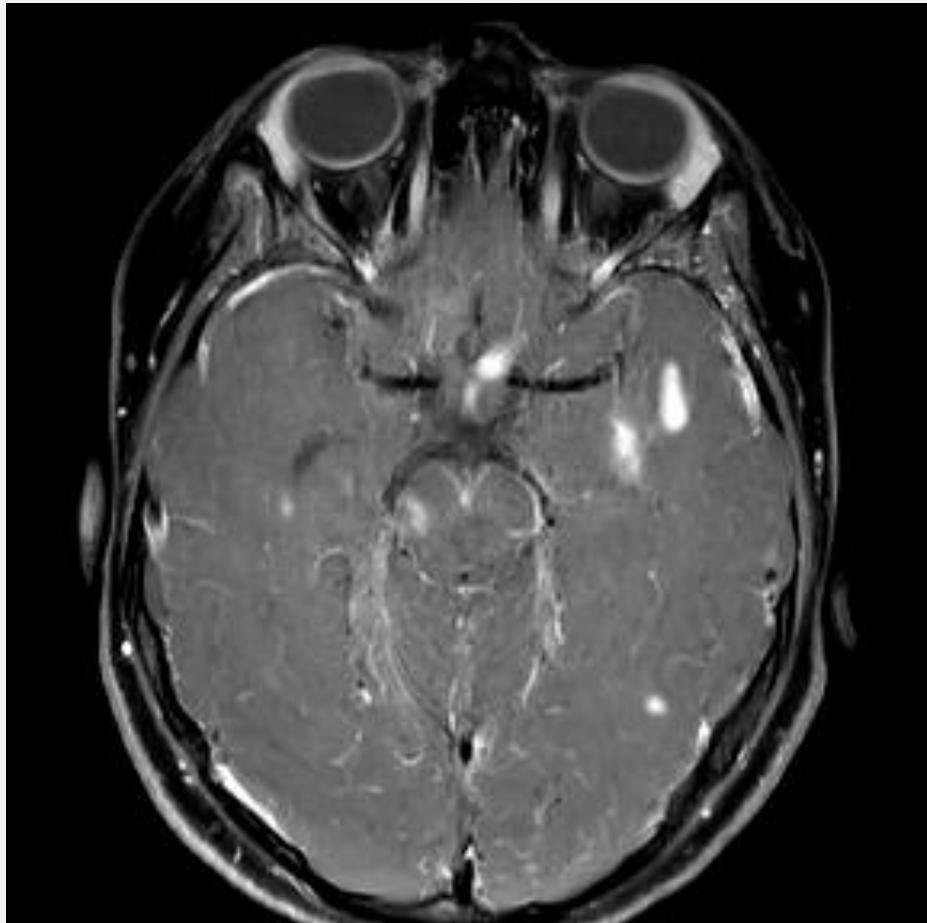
New brain and spinal cord lesions in the same patient from Figure 3. Contrast-enhanced axial T1-weighted image (left) and contrast-enhanced sagittal spine (right) show variably sized enhancing lesions in the left frontal and temporal lobes, right cerebral peduncle, and upper spinal cord. These lesions do not have the typical C-shaped enhancing pattern common in multiple sclerosis.
